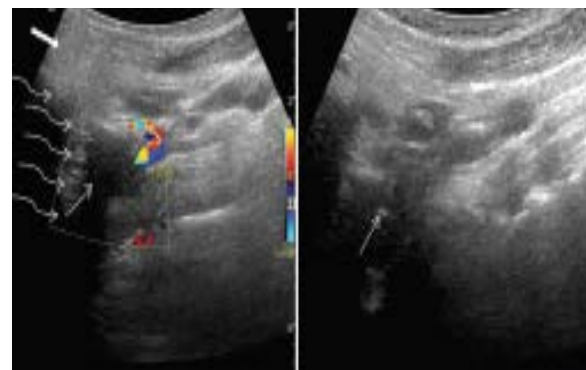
(a) Ultrasound shows a solid, hypoechoic soft tissue in the left post-styloid parapharyngeal space (thin arrow) close to the ICA (colored vessel). Block arrow indicates parotid gland and curved arrows indicate bone causing acoustic shadowing. (b) Ultrasound guided FNAC done with tip of the FNAC needle within the lesion (arrow)
